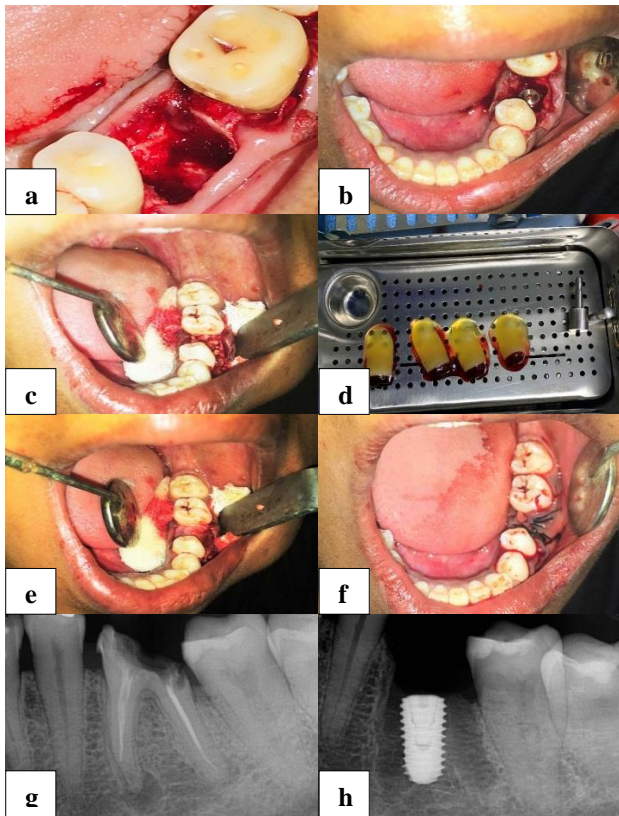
Steps followed for the placement of implant (immediate implant placement in tooth #36) (a) atraumatic tooth extraction preserving alveolar bone integrity, (b) implant placement after sequential drilling, (c) bone graft placement (DFDBA) over the bone defect, (d) PRF membrane prepared, (e) PRF membranes placed over the extraction socket, (f) primary closure achieved using non resorbable silk sutures, (g) preoperative periapical radiograph, and (h) post-operative radiograph.
